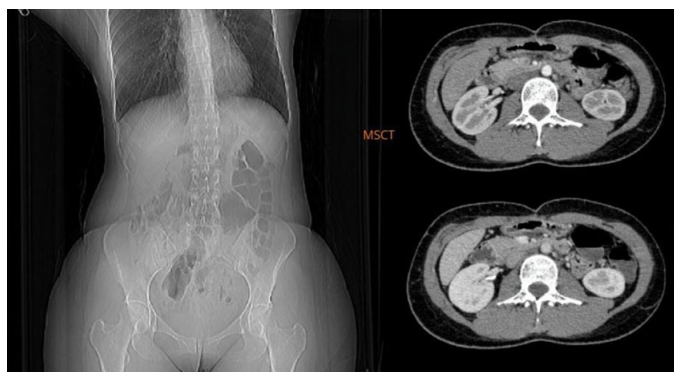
Latest evaluation of abdominal contrast multislice CT (MSCT) with no mass or lymphadenopathies (Oct 25, 2021).
